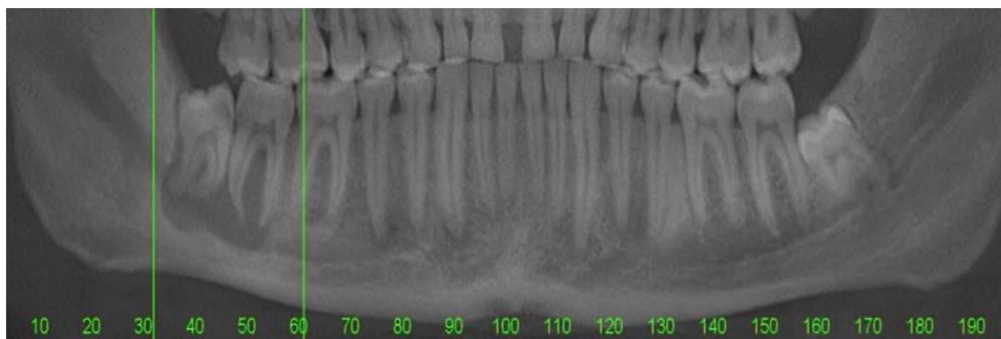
Orthopantomogram showing large radiolucent area associated with teeth 47 and 48 involving inferior alveolar canal.
